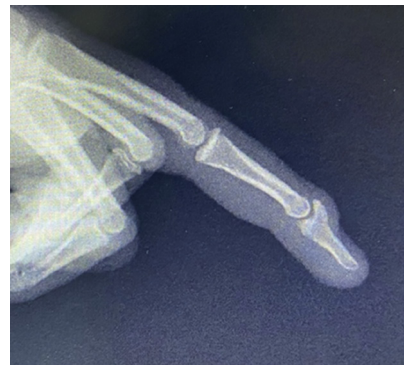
Mallet injury with complete union Lateral X-Ray.
